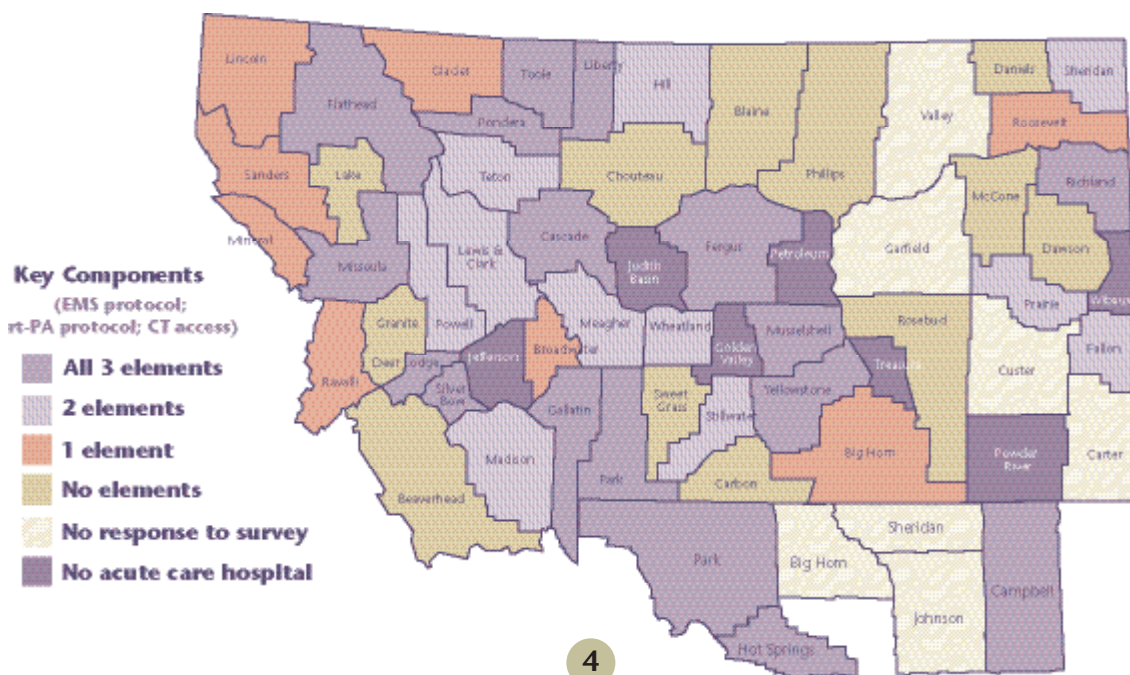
Availability of key components (EMS protocol; rt-PA protocol; 24/7 CT access) for diagnosis and treatment of stroke in Montana and northern Wyoming, 2004, by county.
